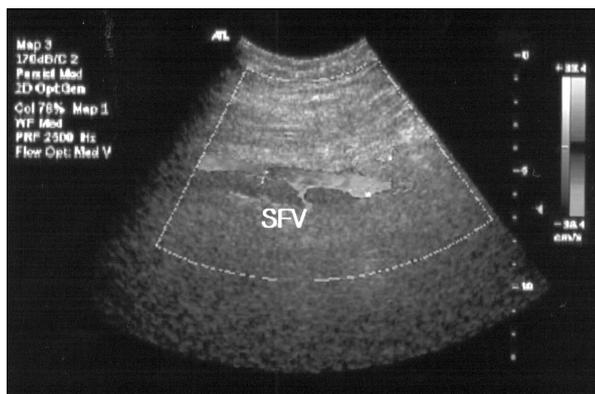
Postoperative color Doppler ultrasound showed patent superficial femoral (SFV) and popliteal veins.
